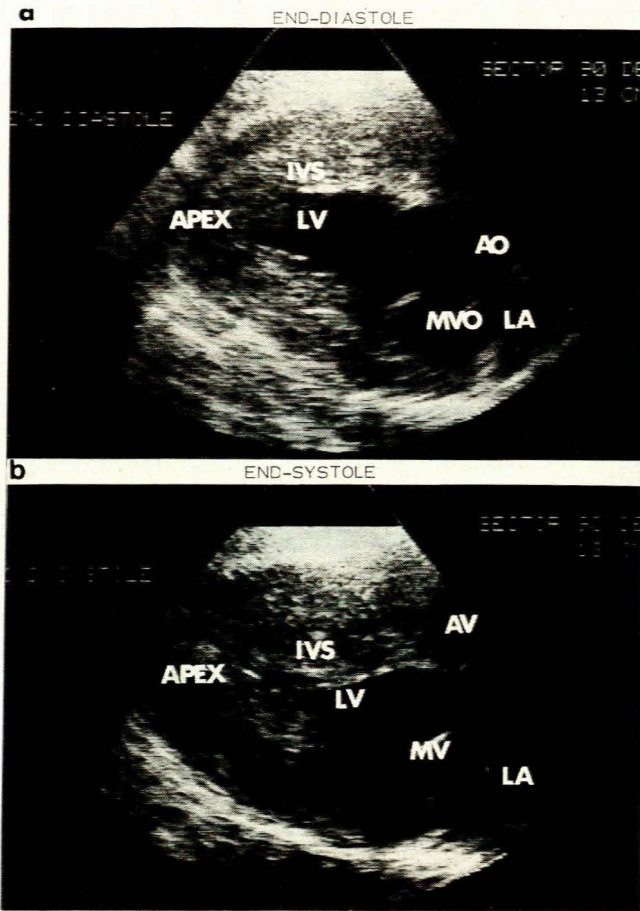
Long-axis two-dimensional (cross-sectional) echocardiogram in (a) end-diastole and (b) end-systole. There is gross thickening of the LVPW giving rise to virtual obliteration of the apex at the end of systole (LV = left ventricle; AO = aorta; LA = left atrium; MVO = mitral valve orifice; AV = aortic valve).
